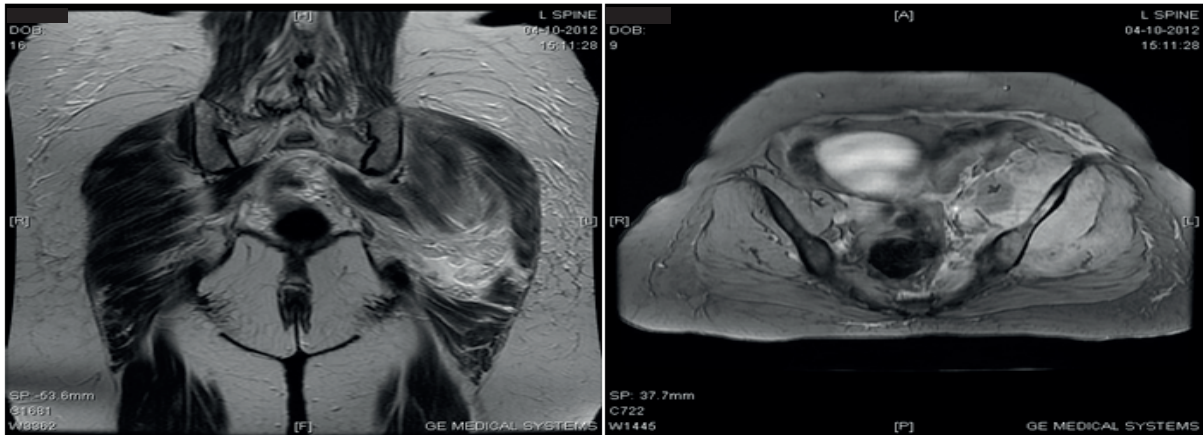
MRI left gluteal region and thigh showing muscle edema and fluid in the intermuscular space
